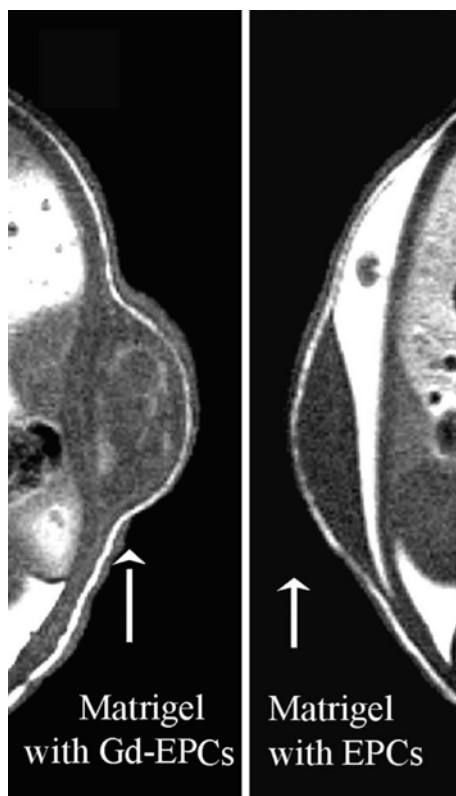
In vivo T_1 -weighted spin echo MR image (7.05 T) of EPCs labeled with GdHPDO3A (*left*). The cells are dispersed into a subcutaneous matrigel plug 7 days after the implantation. On the *right* is the control image of the same in the absence of the paramagnetic label
